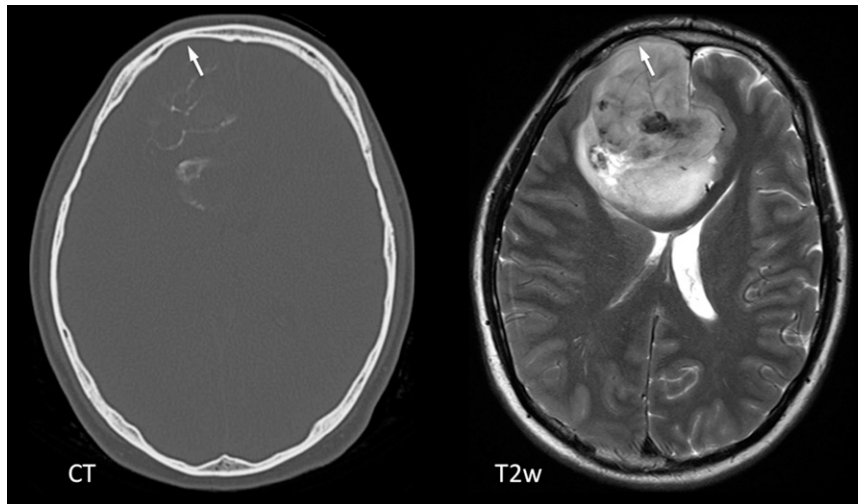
Transverse CT in bone window and T_2 weighted (T2w) MRI sections, showing remodelling of the skull's inner table (arrows) overlying a right frontal lobe oligodendroglioma.
